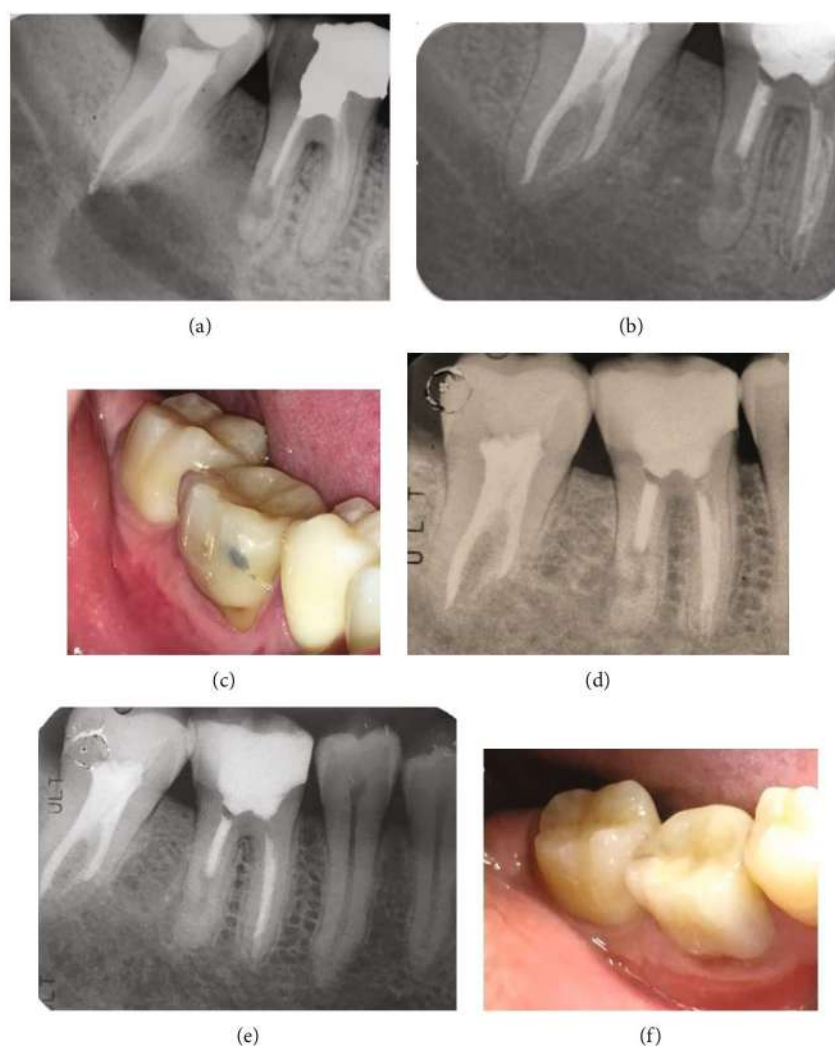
(a) Postoperative periapical radiograph showing root canal treatment of the second mandibular molar. (b) Four-month periapical radiograph showing an increase in radiopacity and trabeculae formation in the area of the intervention. (c) Four-month clinical photograph. (d) Two-year follow-up periapical radiograph. (e) Five-year follow-up periapical radiograph showing both repair of the distal root and bone healing. (f) Clinical photograph at the five-year recall visit.
